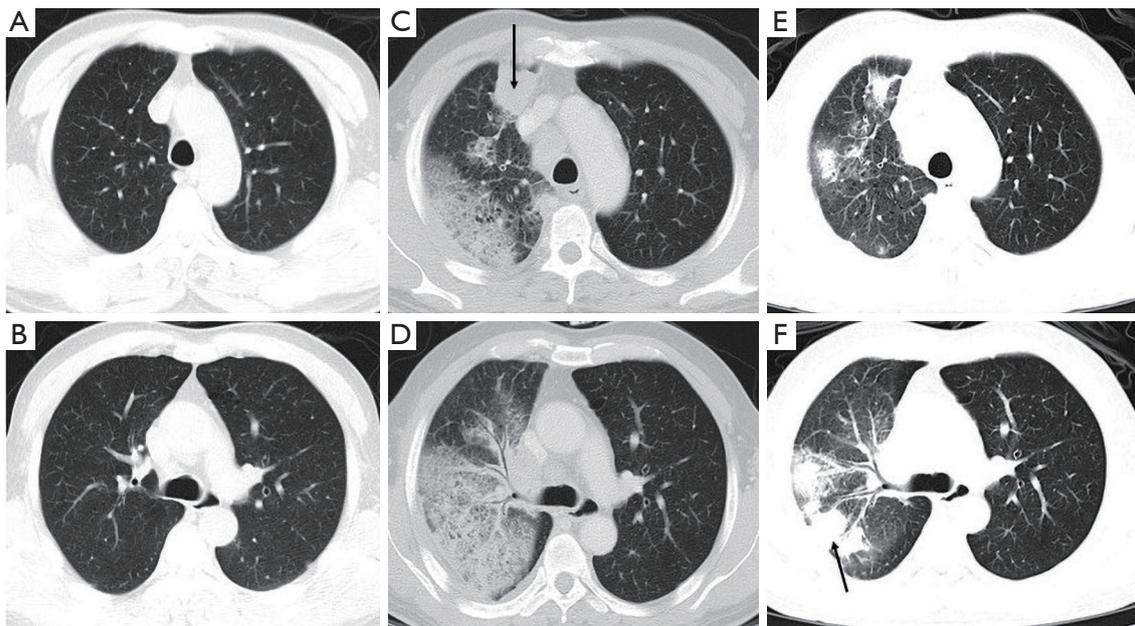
The images of the patient's sequential chest CT scans. In January 2020, there was no significant abnormality (A,B). In June 2020, the first CT scan showed right superior lobe consolidation and right hilar and mediastinal lymph node enlargement (C,D). An ultrasound-guided biopsy of the mass adjacent to the mediastinum (C, arrow) was performed with the discovery of infiltrate of inflammatory cells. After voriconazole administration, the CT scan showed a transformation of the consolidation in the right superior lobe (E,F). A CT-guided lung biopsy was performed on the subpleural nodule (F, arrow), but no tumor cells were found. CT, computed tomography.
